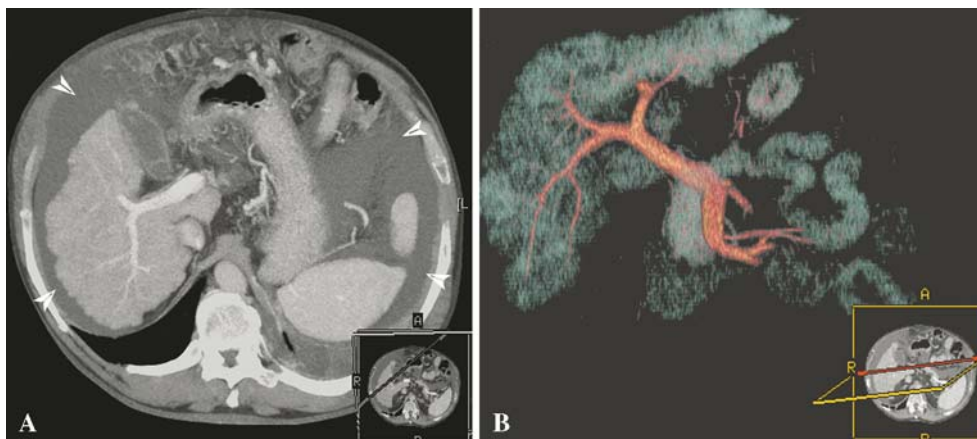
A, B. Before TIPSS placement in 2004, the preinterventional baseline CT scan (venous phase) showed typical signs of liver cirrhosis with ascites (arrowheads), relative atrophy of the right lobe, and a nodular liver contour. We found a technically simple anatomic
